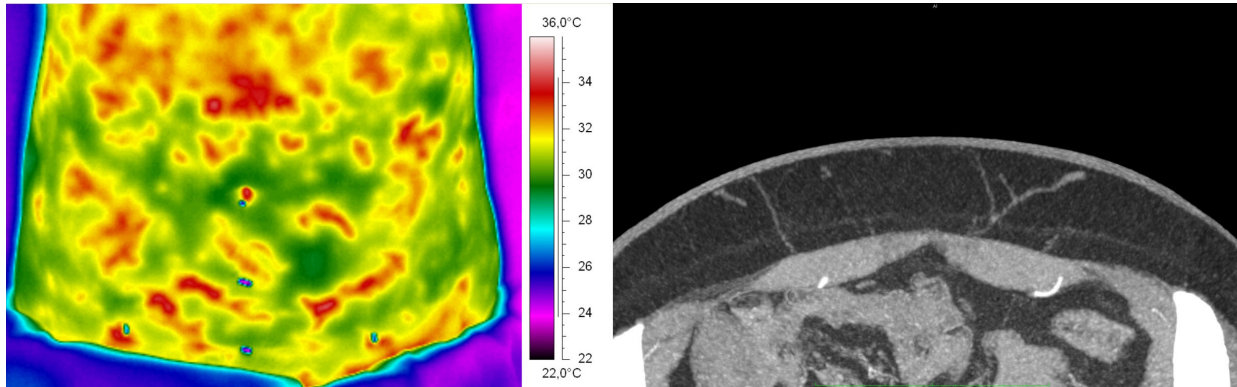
Hot spots on DIRT (left) associated with perforators visible on CTA (right).
